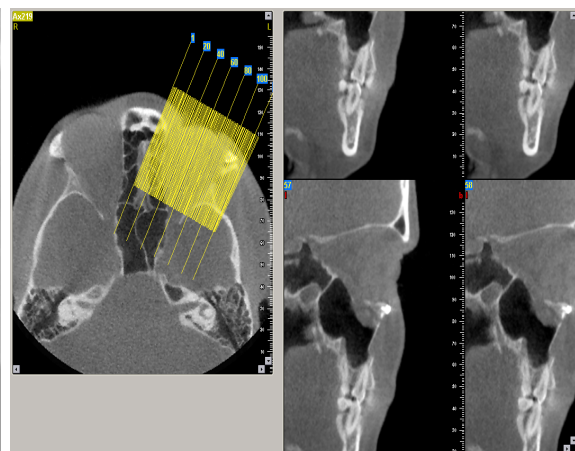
CBCT. Oblique sagittal section evaluation of the displacement and soft tissue down placement within the maxillary sinus
